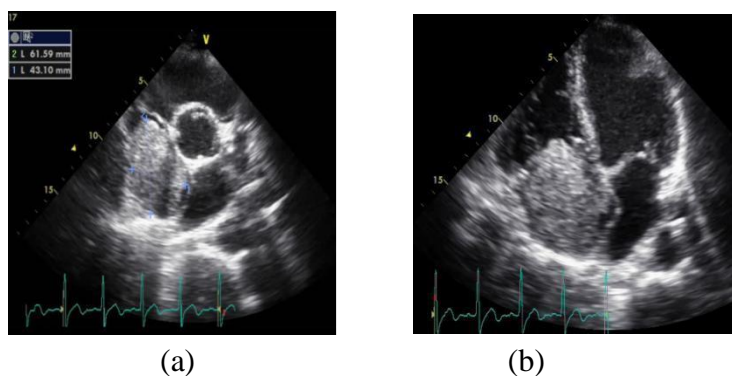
(a, b) Echocardiography images show a dilated right atrium with a right atrial mass filling the right atrial cavity.
